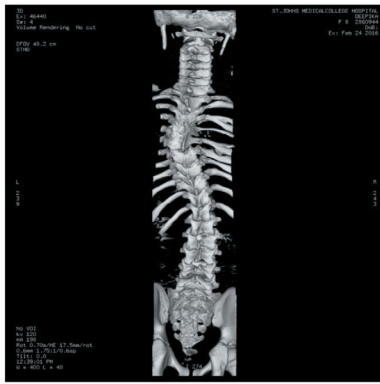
Volume-rendered Coronal CT image showing fusion of posterior elements from D2-D6 vertebral levels with spina bifida from L3 vertebral level downwards to sacral vertebrae//
